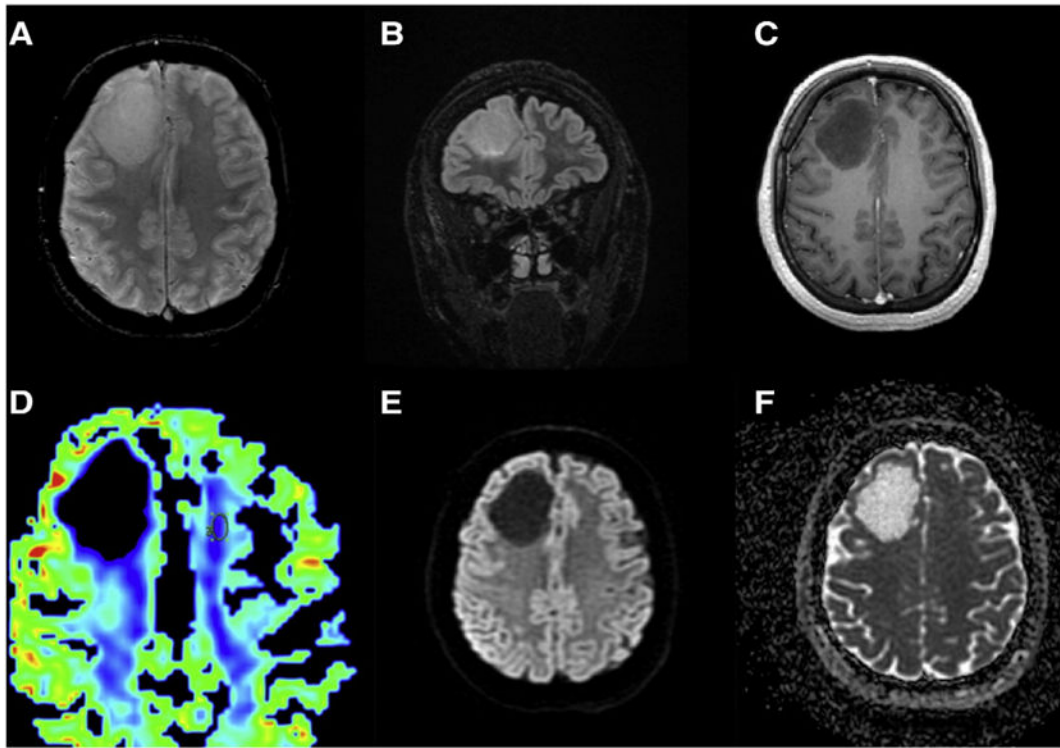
Conventional MR, diffusion-weighted, and MR perfusion imaging: (A) Axial T1-weighted post-gadolinium, (B) coronal T2/FLAIR, (C) axial susceptibility weighted, and (D) dynamic enhanced axial perfusion imaging shows an expansile T2/FLAIR hyperintense nonenhancing mass in the right superior and middle frontal gyri without evidence of superimposed hemorrhagic blood products. Perfusion imaging (D) reveals no significant cerebral blood volume (CBV) as demonstrated by black color within the lesion, matching the black color of sulci. In comparison, white matter is colored shades of blue and cortex is colored red, yellow, and green reflecting higher relative CBV. Diffusion-weighted image (E) and ADC map (F) of the mass demonstrate no evidence of restricted diffusion.
